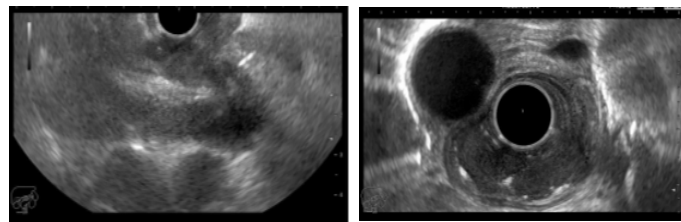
Pre -Treatment Endoscopic Ultrasound: A Mid Esophageal Lesion Appreciated on Endoscopy. The Echoendoscope Showed a Hypoechoic Lesion Arising from the 2nd Layer of Esophageal Wall with A Lobulated Appearance. Although The Lesion Is Well Contained in Most Parts, It Is Seen to Breach the Muscularis and Invade the Serosal Plane in One Aspect (locally invasive). A 7 Mm Paraoesophageal Lymph Node Appreciated. The Main Lesion Was Hypoechoic and Homogenous and Originating from Layer 2-3
